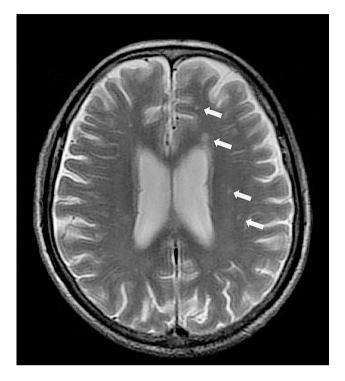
Head magnetic resonance image revealing multiple enhancing nodules in the brain stem, cerebellar vermis, and cerebral hemispheres bilaterally (marked by arrows). Central nervous system infection was highly suspected based on both the clinical symptoms and imaging findings
